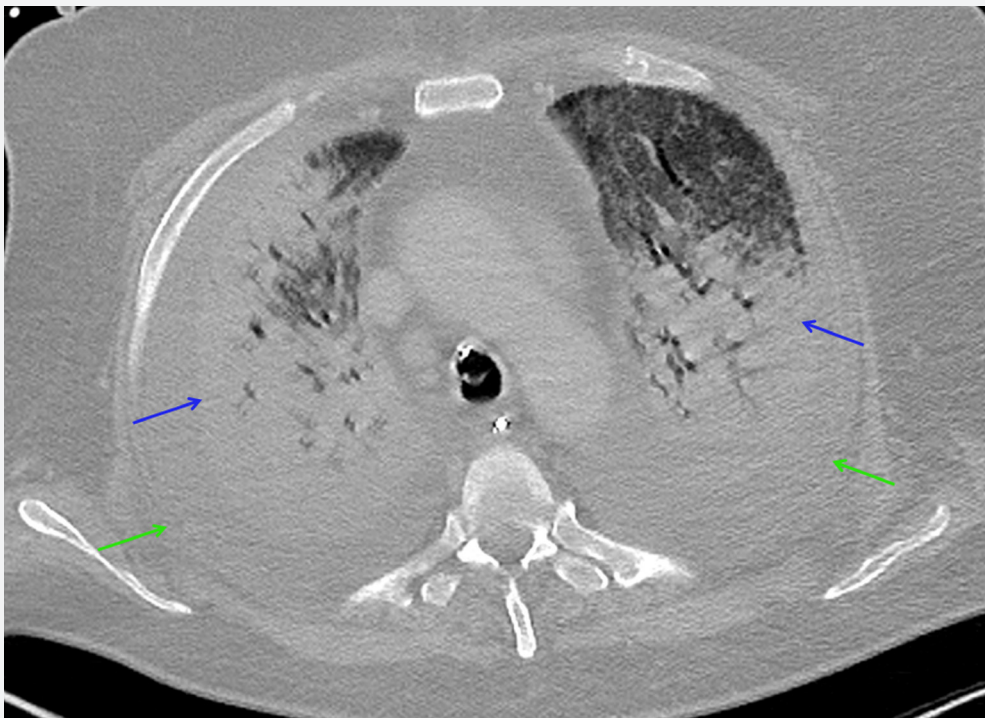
CT images in a 58-year-old patient with advanced stage COVID-19 pneumonia.
